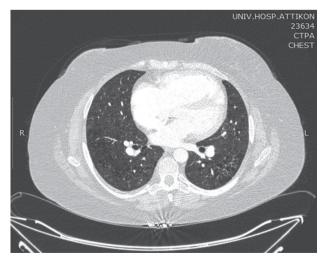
Axial CT image (lung window) of Patient B showing mosaic attenuation, small thin-walled bilateral cysts and severe enlargement of the right cardiac chambers.
